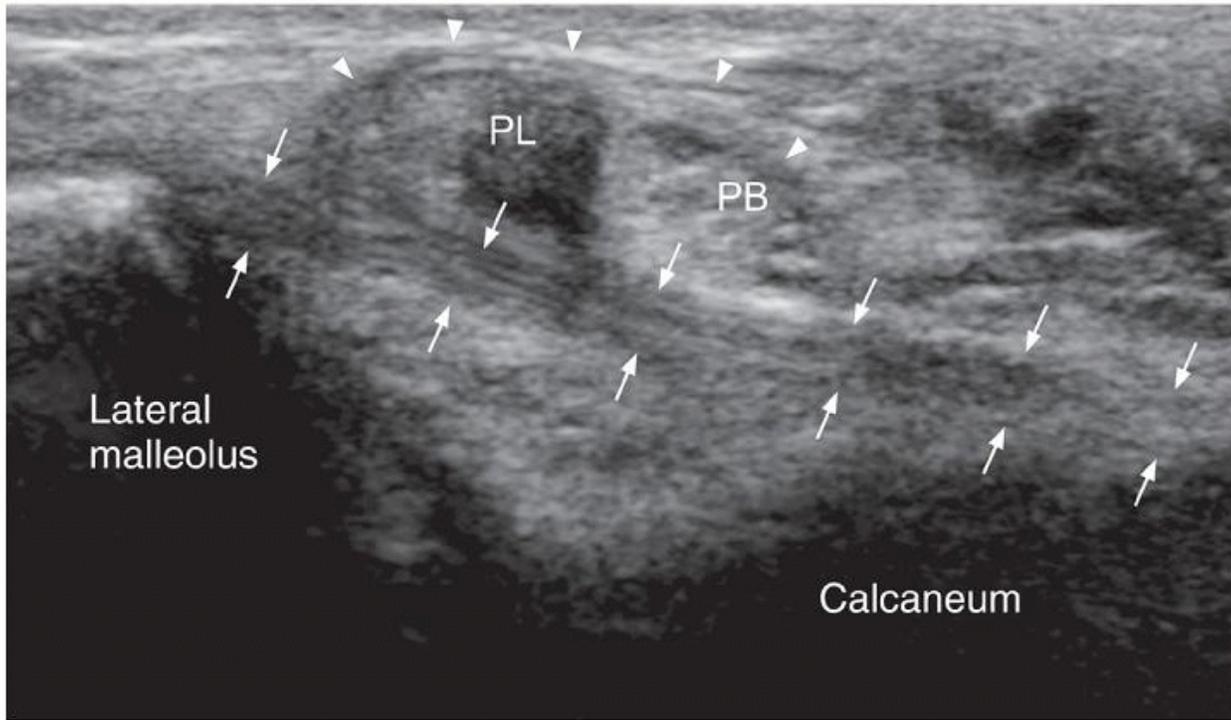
Transverse oblique ultrasound showing the CFL (arrows) extending between the fibular tip and the calcaneum. The ligament lies deep to the peroneus longus (PL) and brevis (PB) tendons. Note also the inferior extensor retinaculum (arrowheads) overlying the peroneal tendons at this location. CFL, calcaneofibular ligament.
